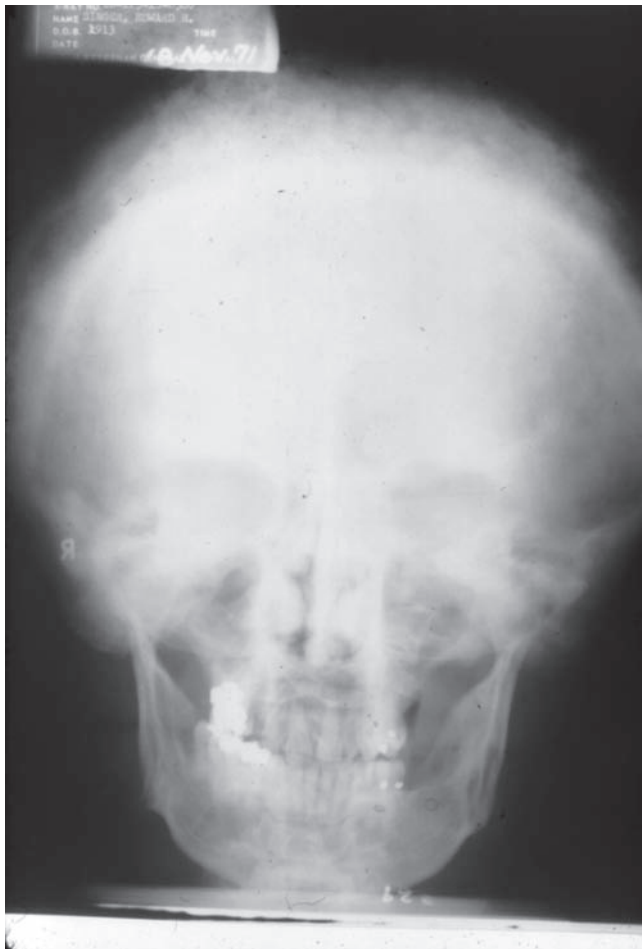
Paget disease. Radiograph showing the cotton-wool appearance of the bone in Paget disease. Note the involvement of the mandible. (Courtesy of Dr. William Carpenter.)
